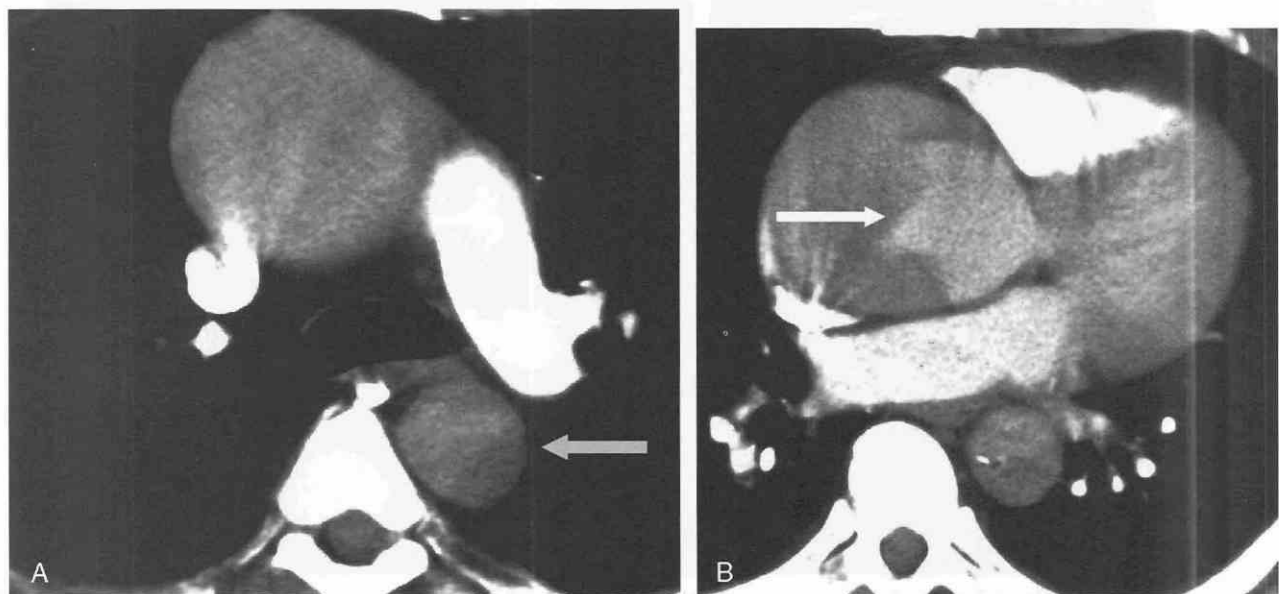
A, Axial CT scan in a patient with suspected aortic dissection. The intravenous bolus of contrast material is early, and visualization of the thoracic aorta is inadequate. Arrow shows descending aorta. B, Axial CT scan at the level of the aortic root shows faint opacification of the aortic root with subtle delineation of ascending aortic dissection (arrow).
